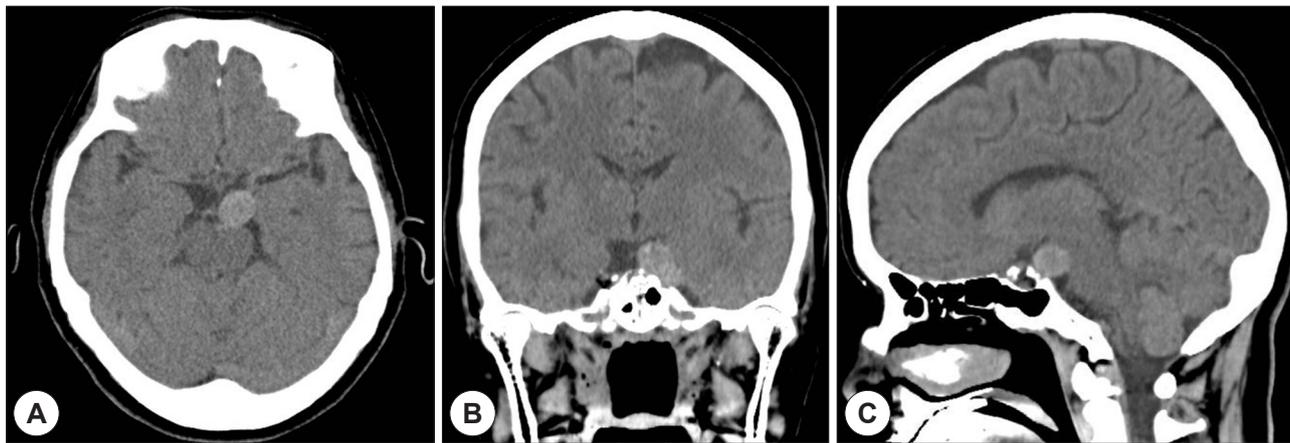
Brain computed tomography reveals a hyperdense focal nodular lesion in the left basal cistern on axial image (A), coronal image (B), and sagittal image (C).
